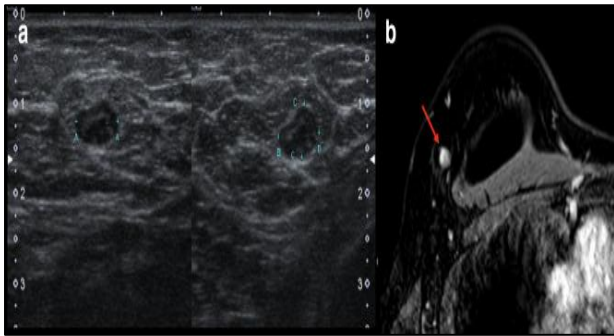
Patient with previous right breast cancer submitted to nipple-sparing mastectomy presented an atypical IMLN in the upper outer quadrant of the same breast at ultrasound (A) and MRI (B), with round shape, eccentric hilum and thickened heterogeneous cortex. Percutaneous ultrasound-guided fine needle aspiration was negative for malignancy and surgical resection confirmed a reactive inflammatory IMLN. IMLN, intramammary lymph nodes.
